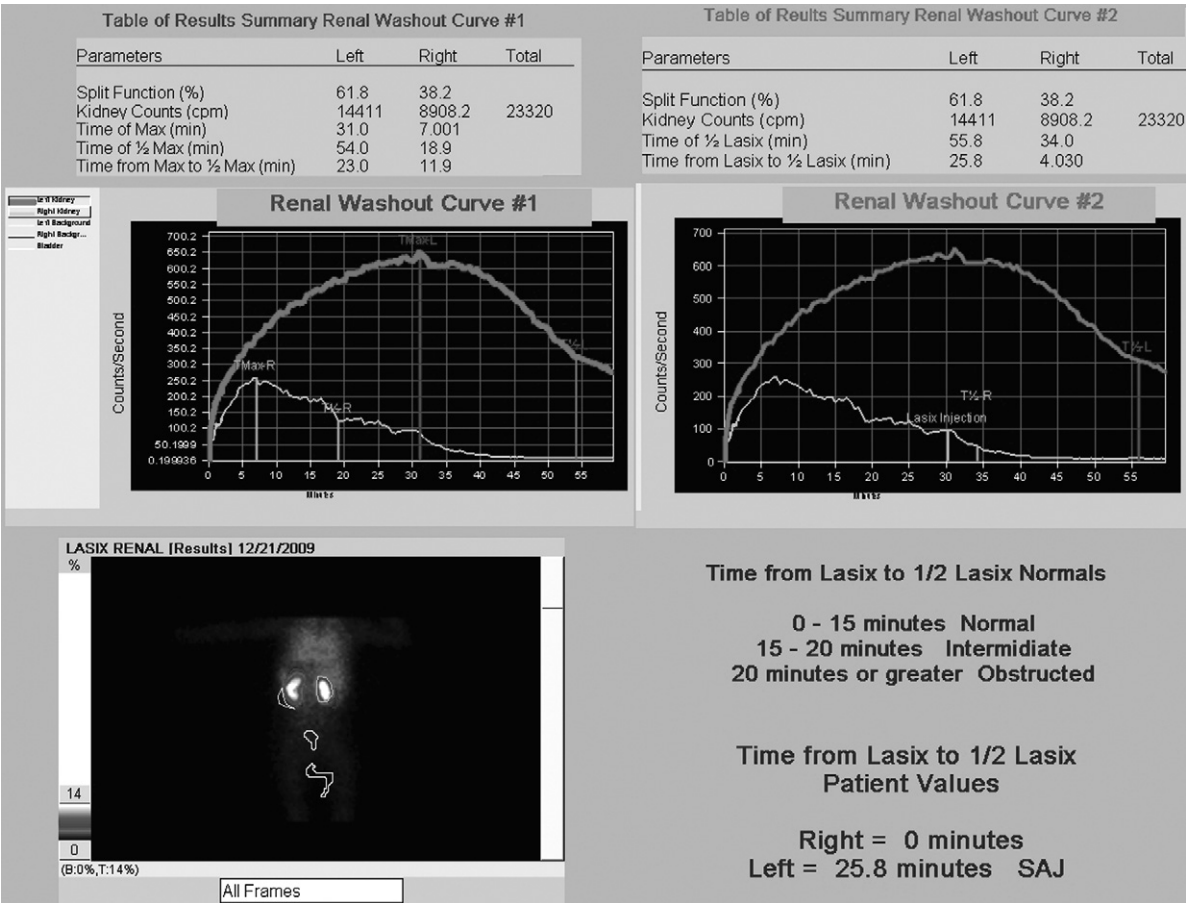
MAG-3 lasix renal scintigraphy: Supranormal renal function of a 6-month-old baby who had the SFU grade 3 hydronephrosis, found postnatally to have high-grade left ureteropelvic junction obstruction. (Courtesy Children's Hospital of Wisconsin, Milwaukee.)
